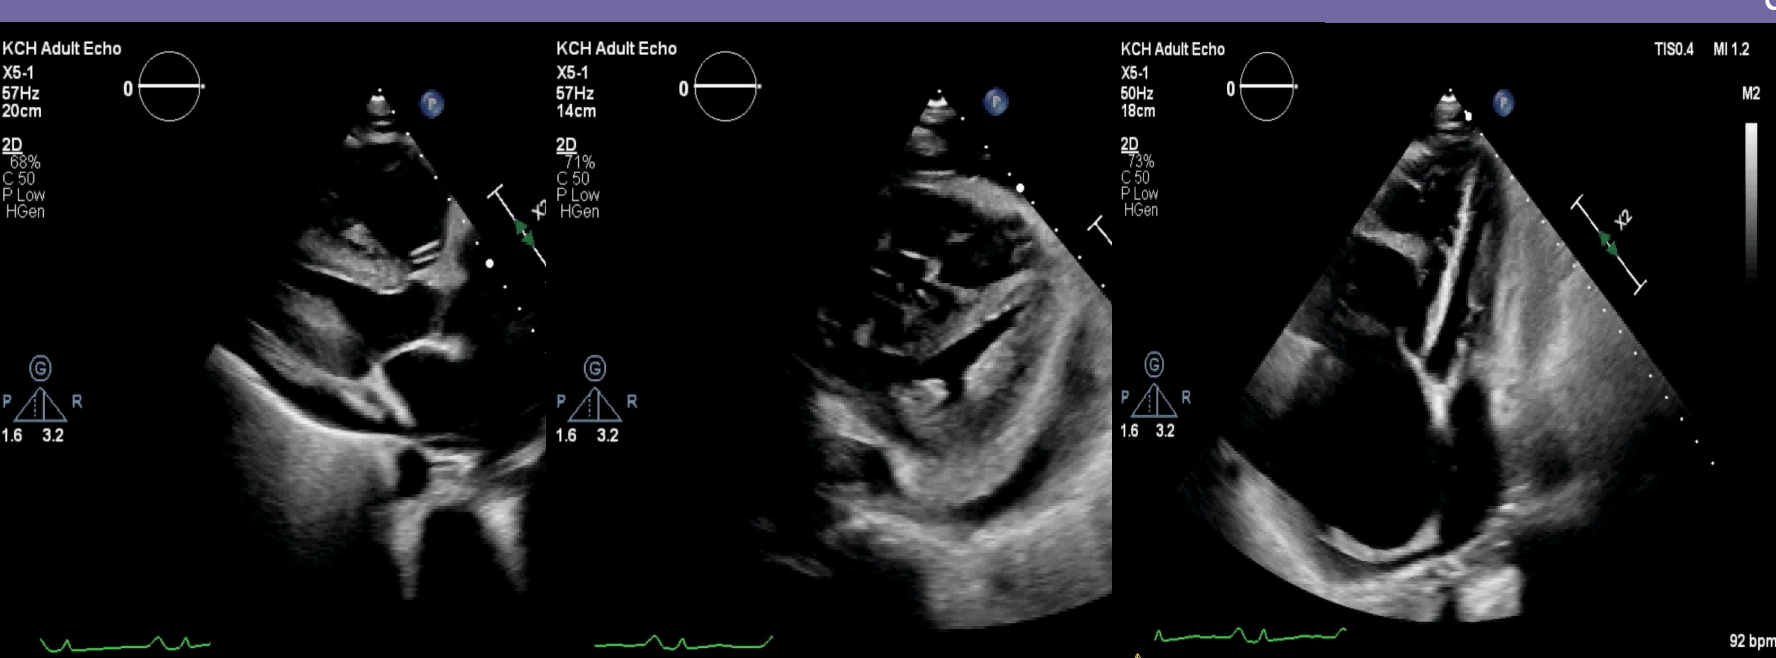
Echocardiographic images
